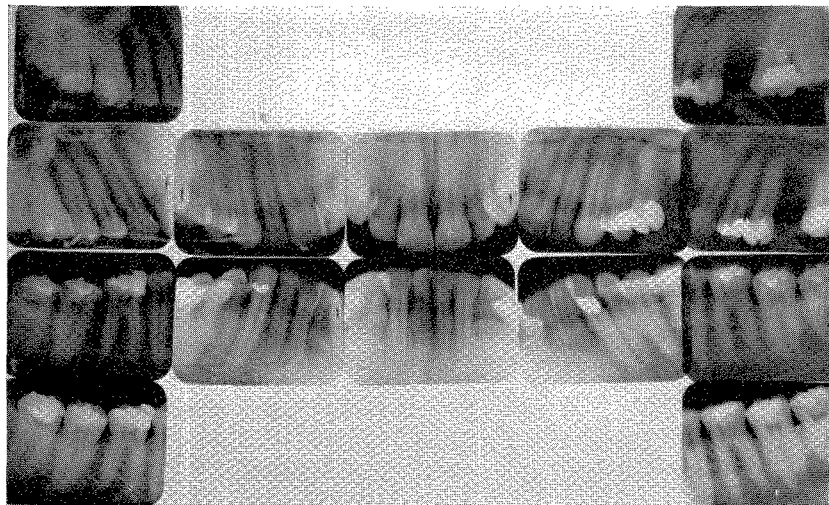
Roentgenograms taken in 1928 when the patient was in her twenties.
